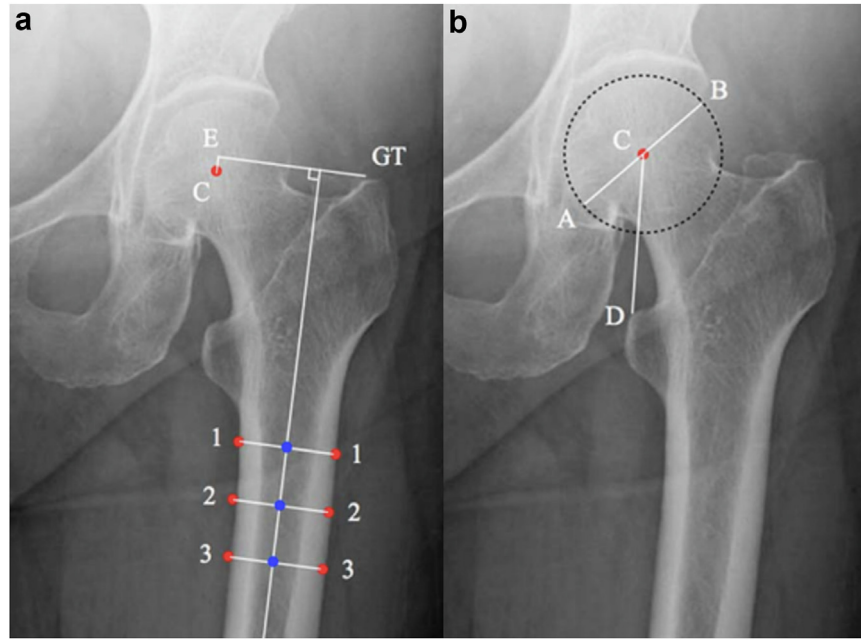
Radiographic measurements of the hip. (a) Measurement of vertical ATD, line C-E and (b) measurement of FNL, line C-D.
